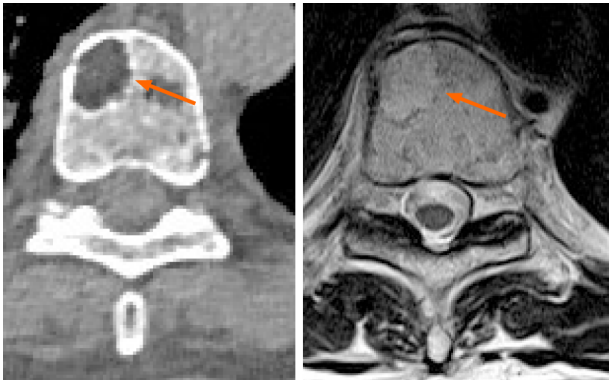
Computed tomography and magnetic resonance imaging of the same lytic lesion located into the vertebral body acquired in the same week for different reasons. No major differences in detection capabilities are evident.
